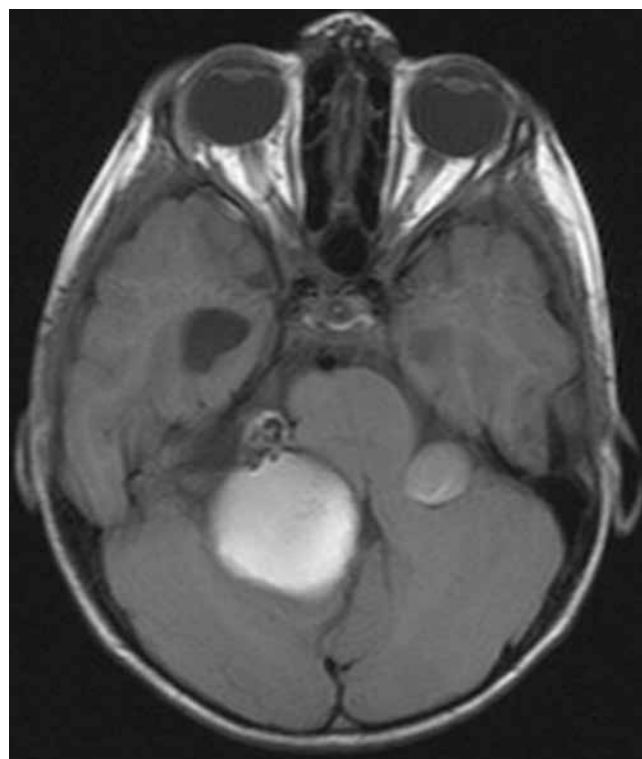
Case 1. Axial MR image obtained at 6 months, demonstrating no progression of the varix, stable mass effect, and improvement in ventriculomegaly.
